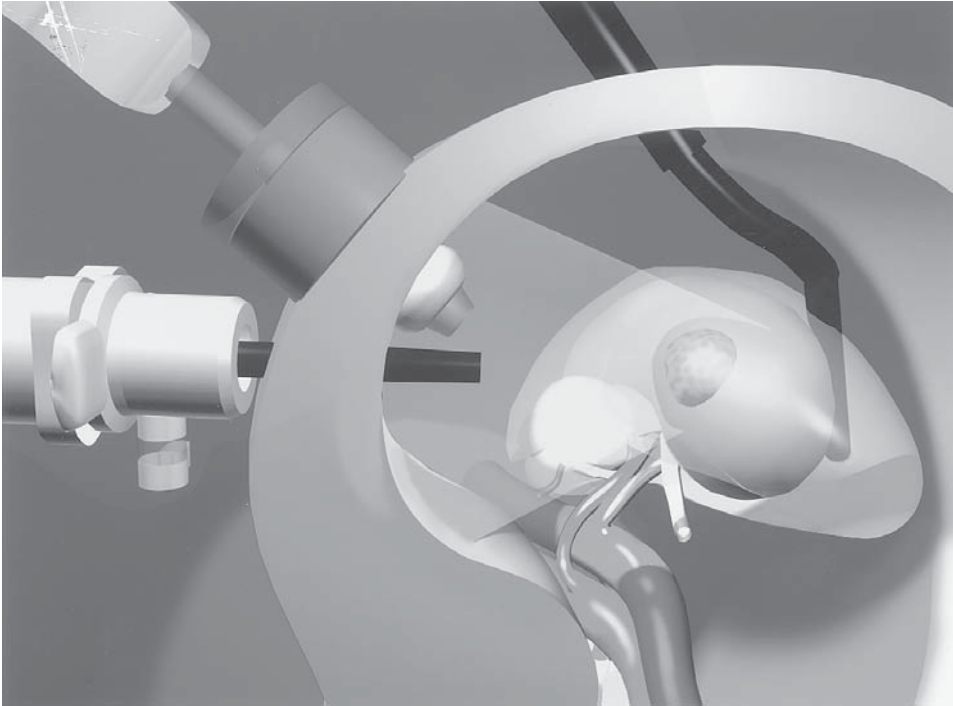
Real-time, steerable, laparoscopic ultrasonography of the renal tumor. The flexible ultrasound probe is placed in direct contact with the surface of the kidney opposite to the tumor. This allows the inner margin of the evolving ice-ball to be accurately imaged in real-time fashion.
